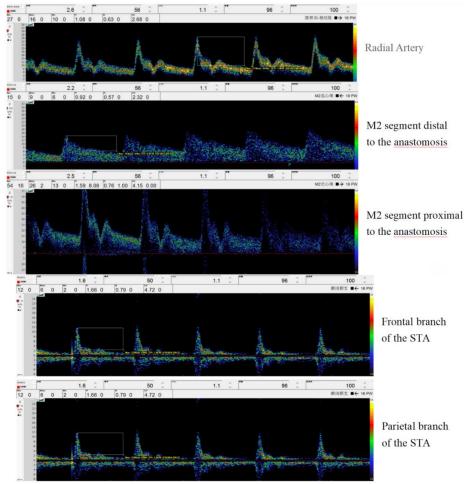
Intraoperative flow monitoring using transcranial Doppler and indocyanine green videoangiography.
